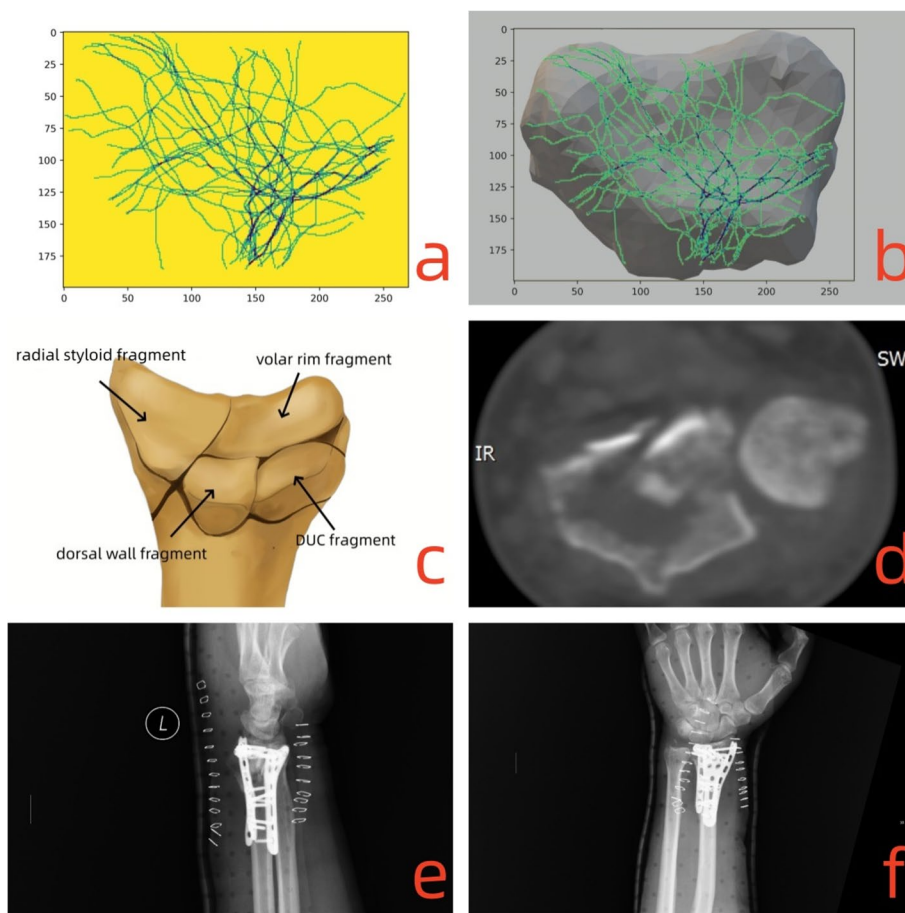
For type 3.2 DRFs, the fracture lines derived from the sigmoid notch, dorsal side, radial side and volar side, and crossed along the interfossal ridge forming like “+” shape. The morphological characteristics and the clinical treatment were shown as follows: a-b) the fracture lines clustered and covered on the intra-articular surface; c) the model for type 3.2 DRFs; d) the CT scan for the fracture lines at the articular surface; e-f) postoperative posteroanterior and lateral X-ray images
